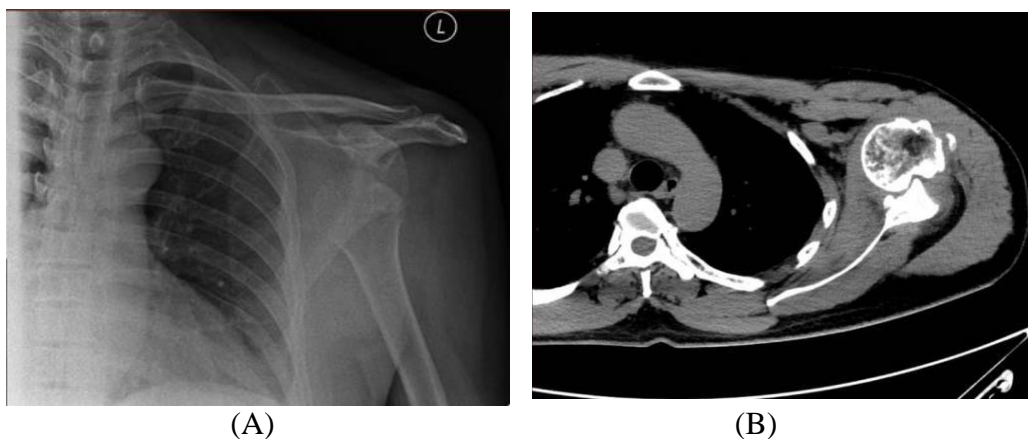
(A). Plain X-ray on the Left shoulder shown a humeral head dislocation from the glenoid bone. (B) Hill- Sachs lesion shown and no glenoid bone loss noticed.
